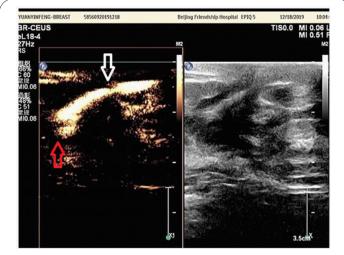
Shows highlighted ducts filled with the contrast agent of Sino Vue; filling stopped by red arrows and narrowed by white arrows taken as ductal nodule; B: Shows the image of routine ultrasound under the same probe.
